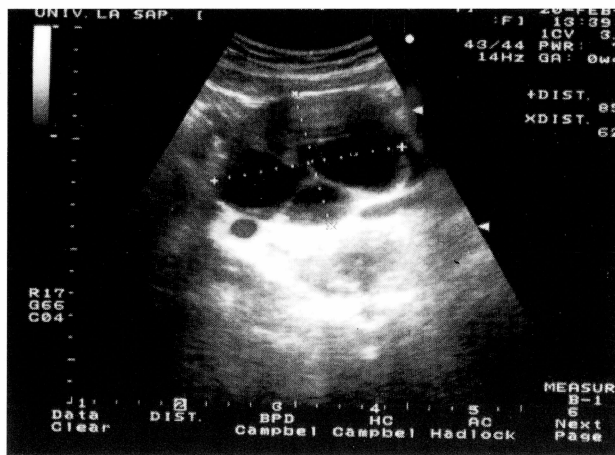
Ultrasound showing a complex and multicystic mass of the right ovary (struma ovarii).
